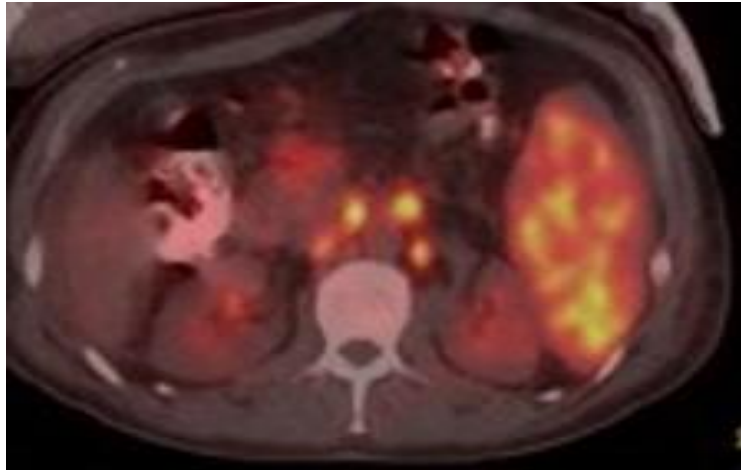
Forty two years old male patient who attended hospital for abdominal pain and ultrasonography results revealed caecal fistula and severe abdominal enlarged lymph nodes and splenomegaly. The F18 FDG PET/CT showed significant FDG uptake at the abdominal sites (bowel Wall, lymph nodes and spleen) that were determined by sonography.
